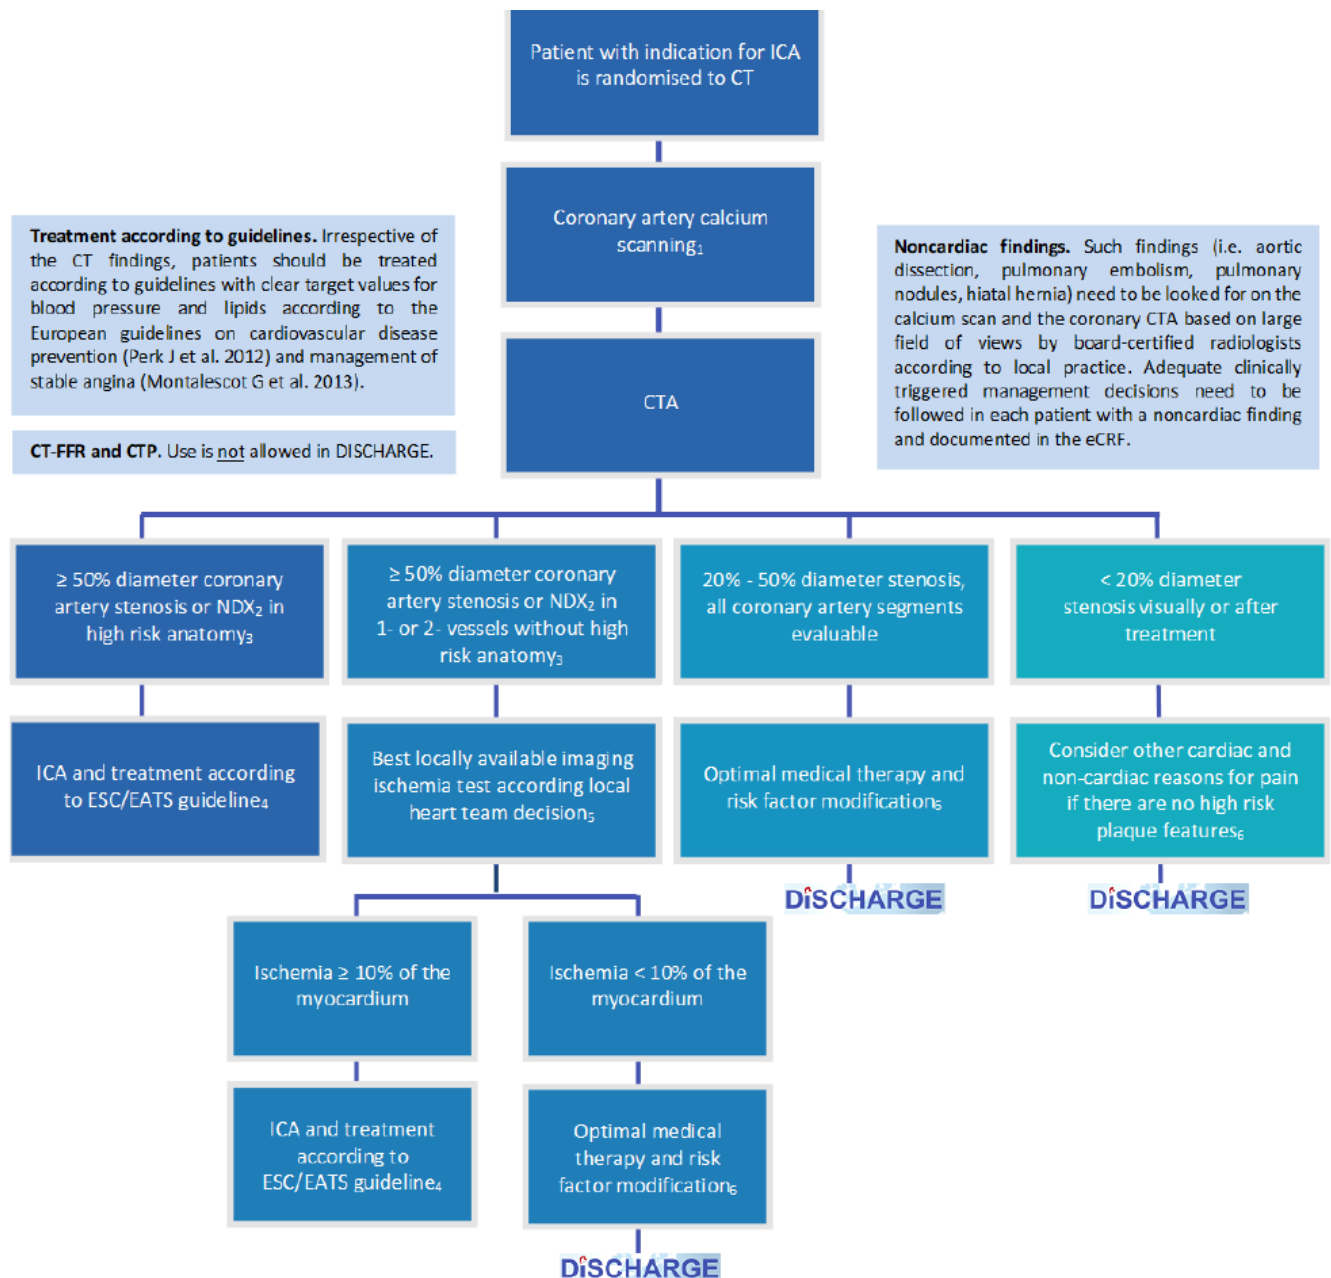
Decision analytic model structure for CT compared to ICA.
